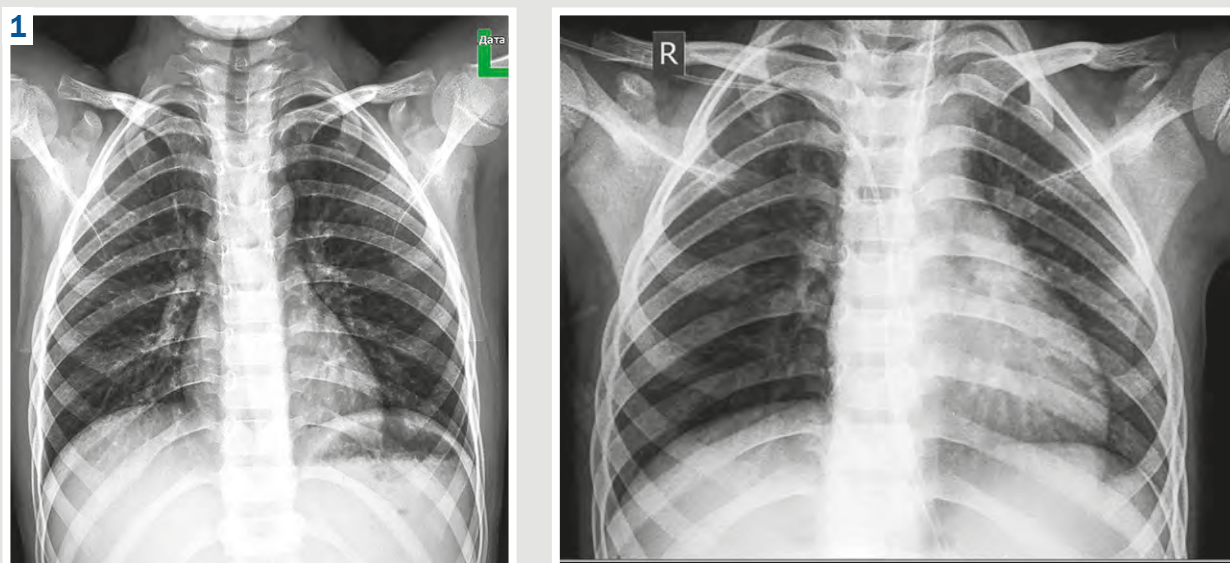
Chest X-ray upon admission to the Pediatric ICU of the PNE "ZRCDCPP" ZRC.
